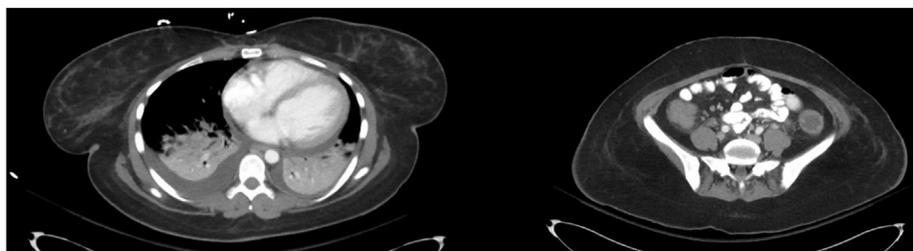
CT abdomen and pelvis showed moderate right sided and small left-sided pleural effusion, bilateral consolidations, and colon wall thickening.
